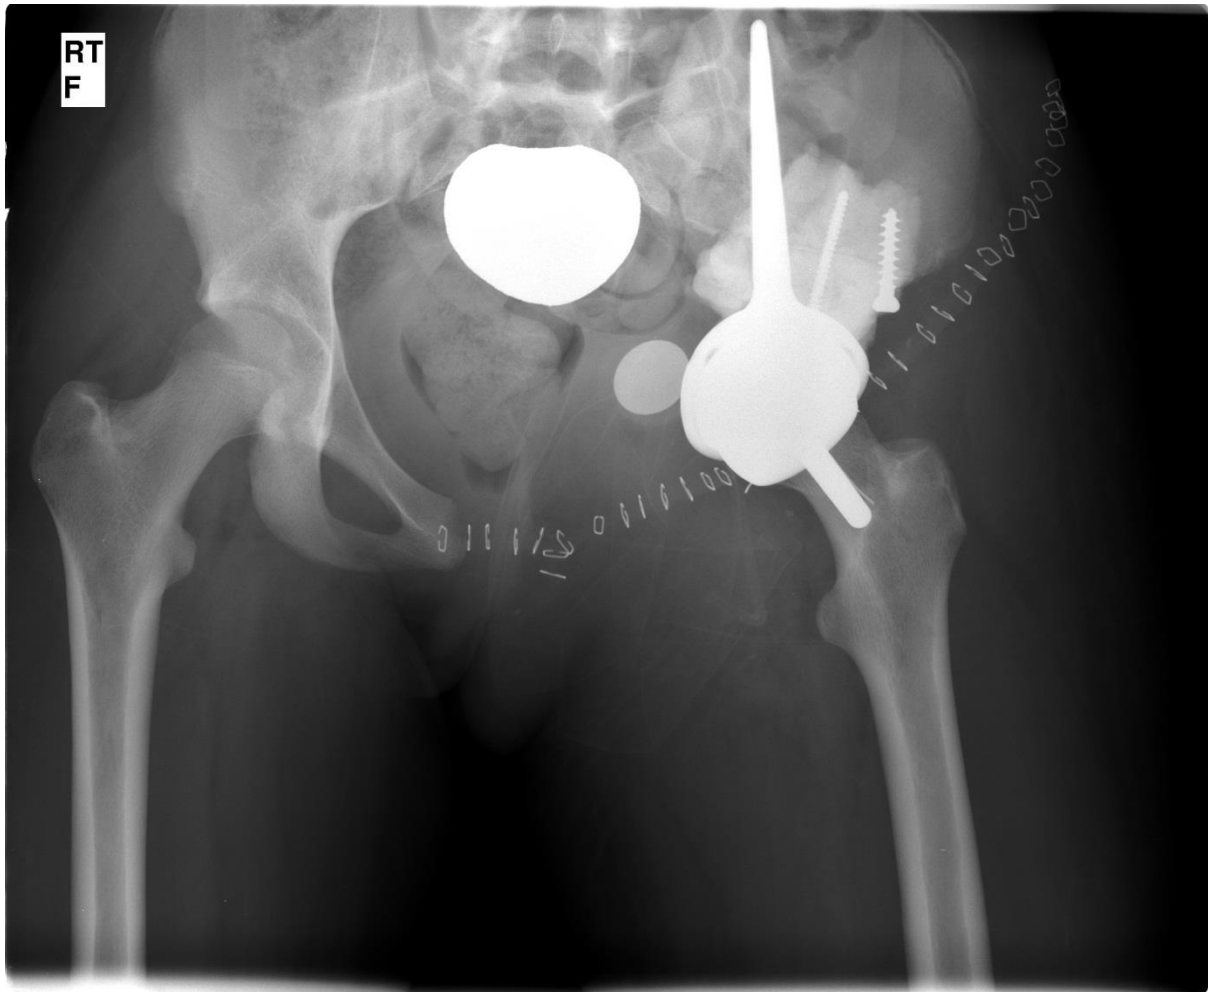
An AP radiograph of pelvis showing an endoprosthetic replacement of pelvis for type II/III tumour
